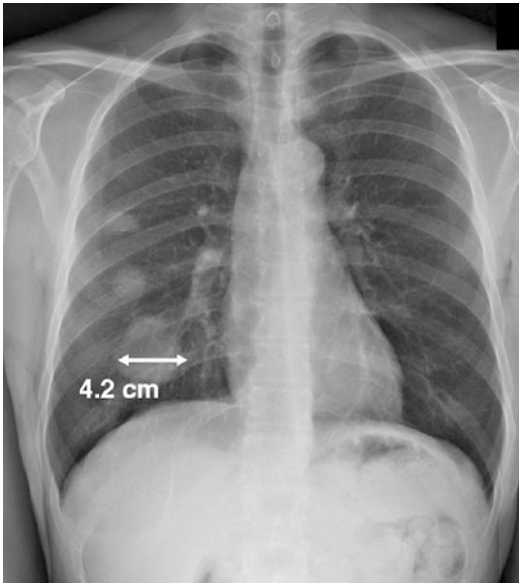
Measurable lesions according to RECIST. Frontal chest radiograph in 52-year-old woman shows mass with longest diameter of 4.2 cm (arrow) representing lung cancer, which meets criteria for measurable lesion on chest radiography (longest diameter ≥ 20 mm). (Reprinted with permission from AJR Am J Roentgenol. 2010;195: 281–289)
